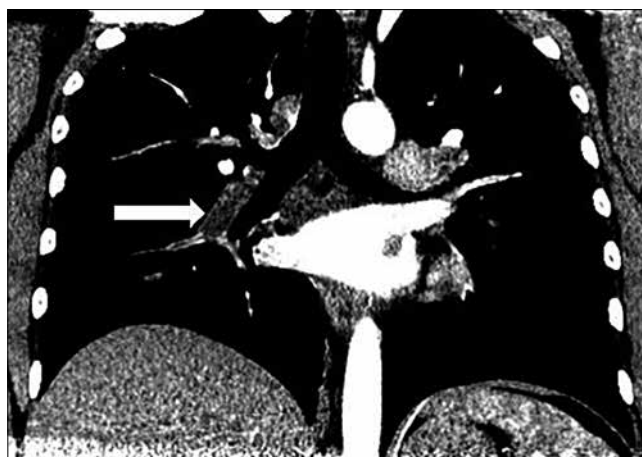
Pulmonary CT angiography – the defect in contrast fillings in the intermediate artery on the right side.
